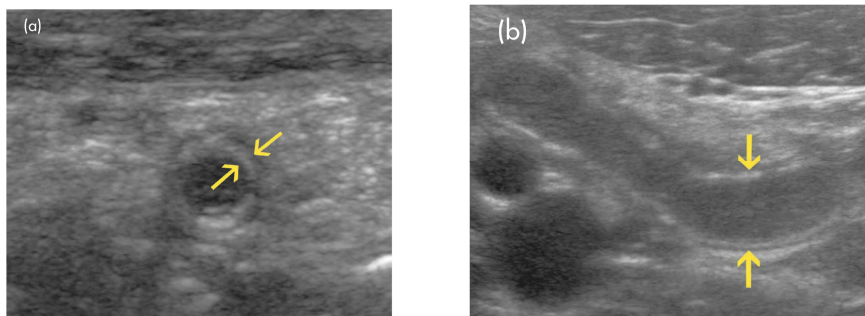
Ultrasonography of an acutely inflamed appendix (arrows): (a) transverse, and (b) longitudinal.
